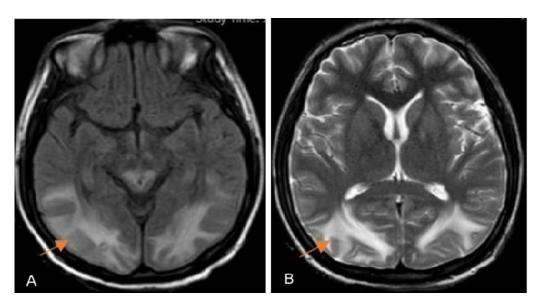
Hyperintensity in the occipital regions bilaterally on axial T2-FLAIR MRI image (A) and axial T2-weighted MRI image (B).
